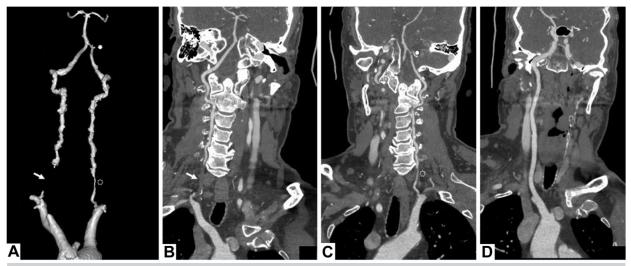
Three-dimensional reconstruction (A) and curvilinear reconstructions of the preoperative computed tomography angiography (CTA) of the right vertebral artery (VA; B), left VA (C), and right internal carotid artery (ICA; D) showing occlusion of the right VI segment (*arrow*), a tight atherosclerotic stenosis of the left VI (*empty star*), and a tight stenosis of the left V4 (*full star*).
